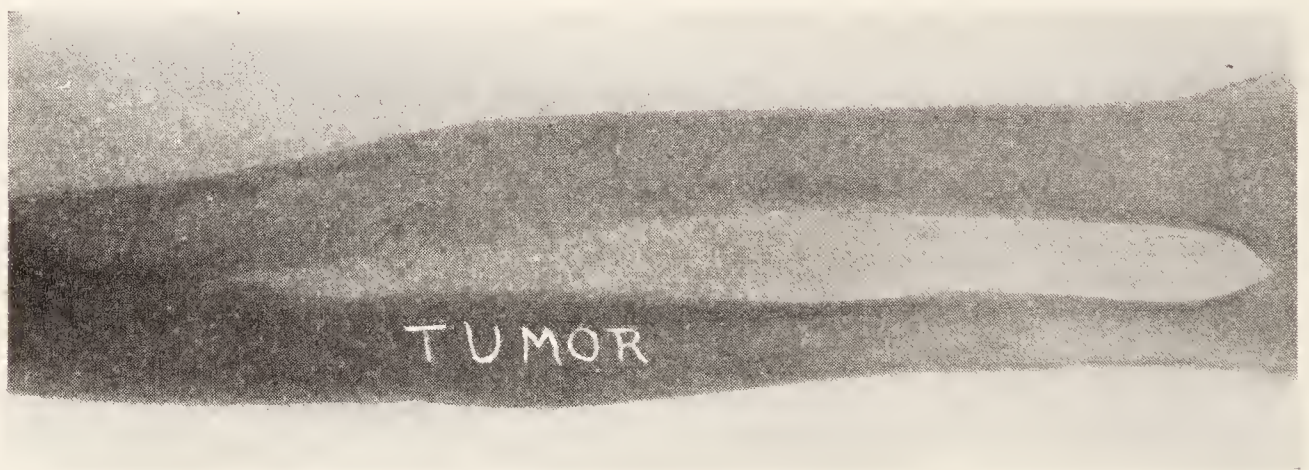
Forearm October 5, three weeks before third admission, after X-ray treatment.
